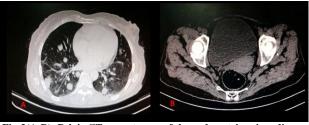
(A-B): Pelvic CT-scan: tumor of the endometrium invading the myometrium with pulmonary secondary locations
